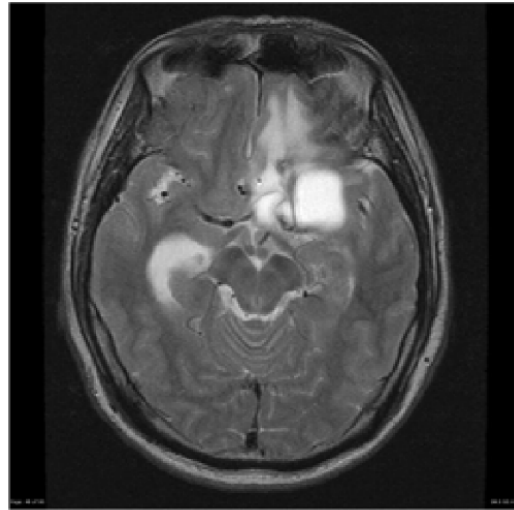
Resized MRI image.
